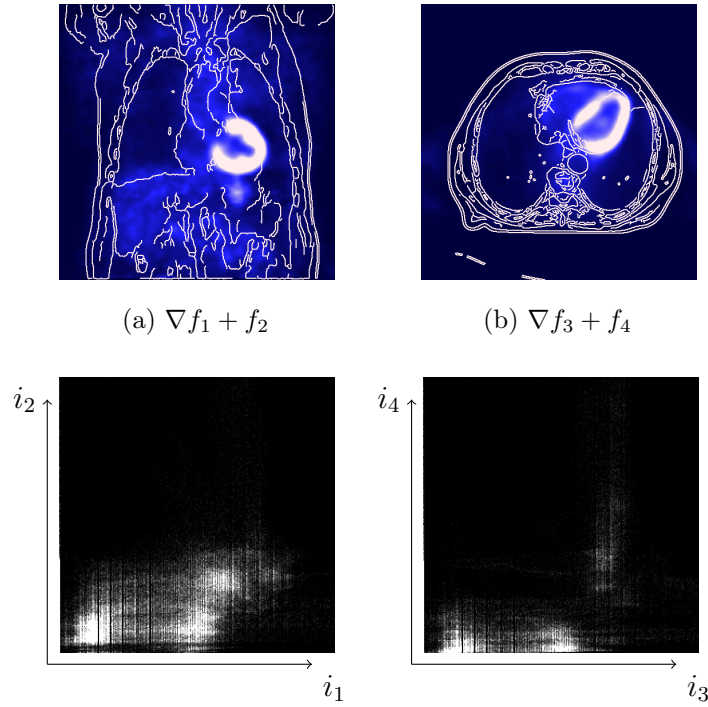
(a)-(b) Two PET slices overlaid with image edges from CT visualizing the image alignment in coronal and axial view. Bottom row shows corresponding joint intensity distributions. Bright colors indicate a higher count of PET/CT intensity pairs, whereas dark areas denote their absence in the medical data.
